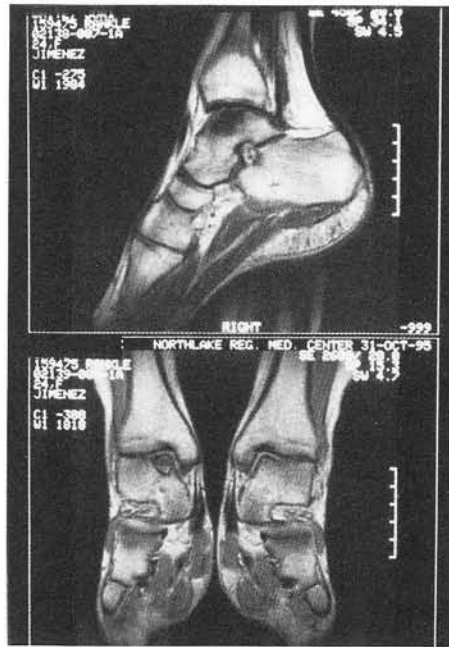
Sagittal and coronal MRI.
